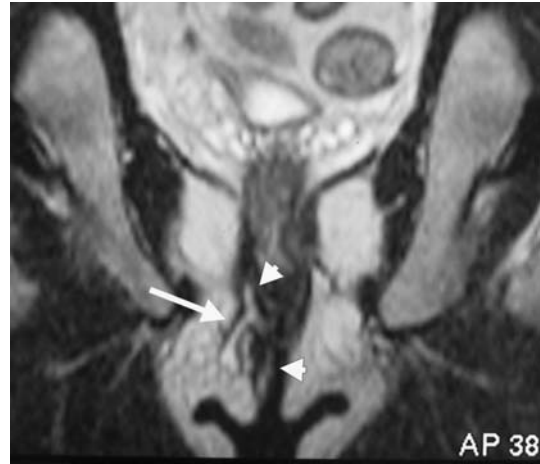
Coronal T2-weighted image shows a right-sided transsphincteric fistula (*arrow*) with a secondary track (*arrowheads*) running down and posteriorly.
